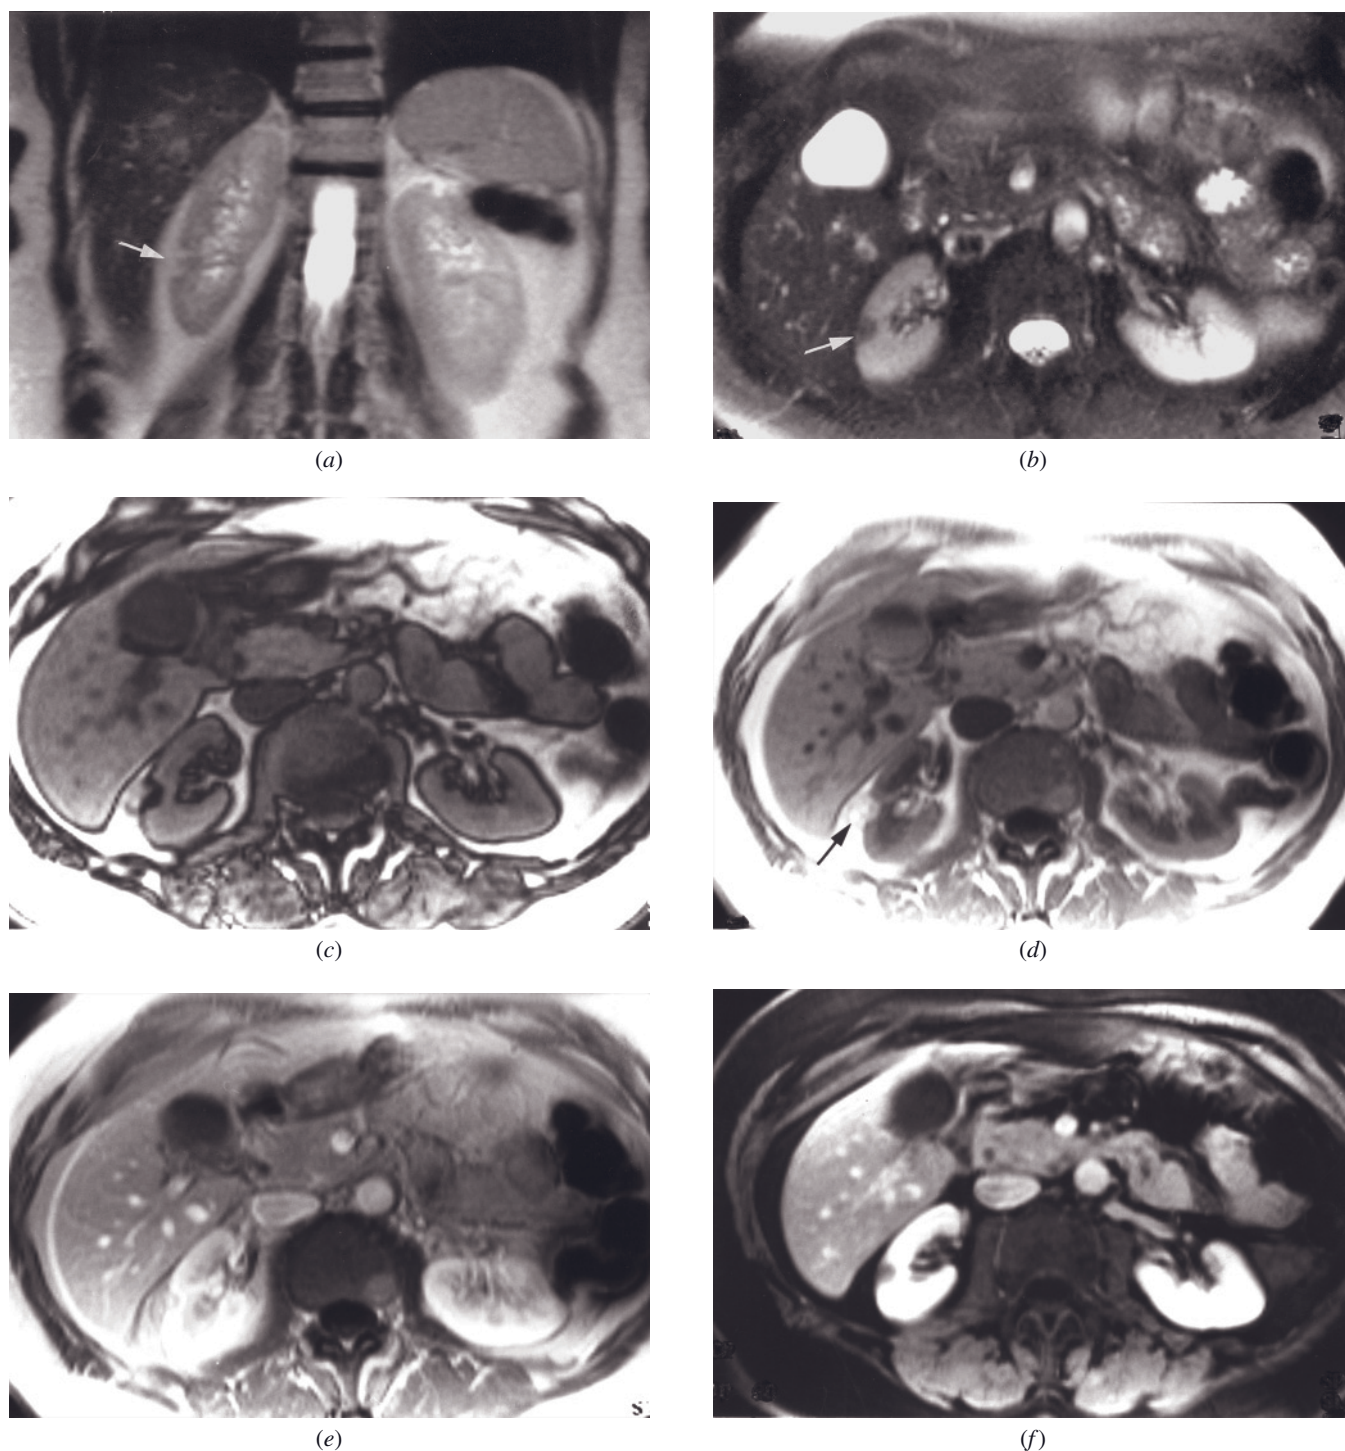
Fat effects, gadolinium effects, and their distinction. Coronal T2-weighted single-shot echo-train spin-echo (*a*), T2-weighted fat suppressed single-shot echo-train spin-echo (*b*), T1-weighted out-of-phase SGE (*c*), T1-weighted in-phase SGE (*d*), 1-min postgadolinium SGE (*e*), and 1.5-min gadolinium-enhanced fat-suppressed SGE (*f*) images. It is always useful to compare noncontrast nonsuppressed (*a*) and fat suppressed (*b*) sequences to ascertain whether high-signal structures observed on nonsuppressed sequences represent fat, or lower-signal structures observed on fat-suppressed sequences represent fat and not low-fluid-content solid masses. Comparing out-of-phase (*c*) to in-phase (*d*) sequences also permits characterization of fatty tumors. In this patient, a right renal angiomyolipoma is present that on the basis of the fat-suppressed T2-weighted sequence alone (arrow, *b*) may be considered a possible renal cancer or hemorrhagic cyst because of its low signal. Comparison with the non-fat-suppressed sequence (*a*) reveals that the tumor is high signal intensity in the absence of suppression (arrow, *a*), showing that it represents fat. Another approach is to show that the high-signal mass on the in-phase image (arrow, *d*) develops a phase cancellation black ring interface with renal parenchyma on the out-of-phase image (*c*). By noting that the mass is fatty, then high signal on early postgadolinium images (arrow, *e*) can be recognized as a fat effect, and not enhancement, and loss of signal on the 1.5-min gadolinium-enhanced fat-suppressed image is not misinterpreted as washout, but correctly observed as a fat suppression effect.
